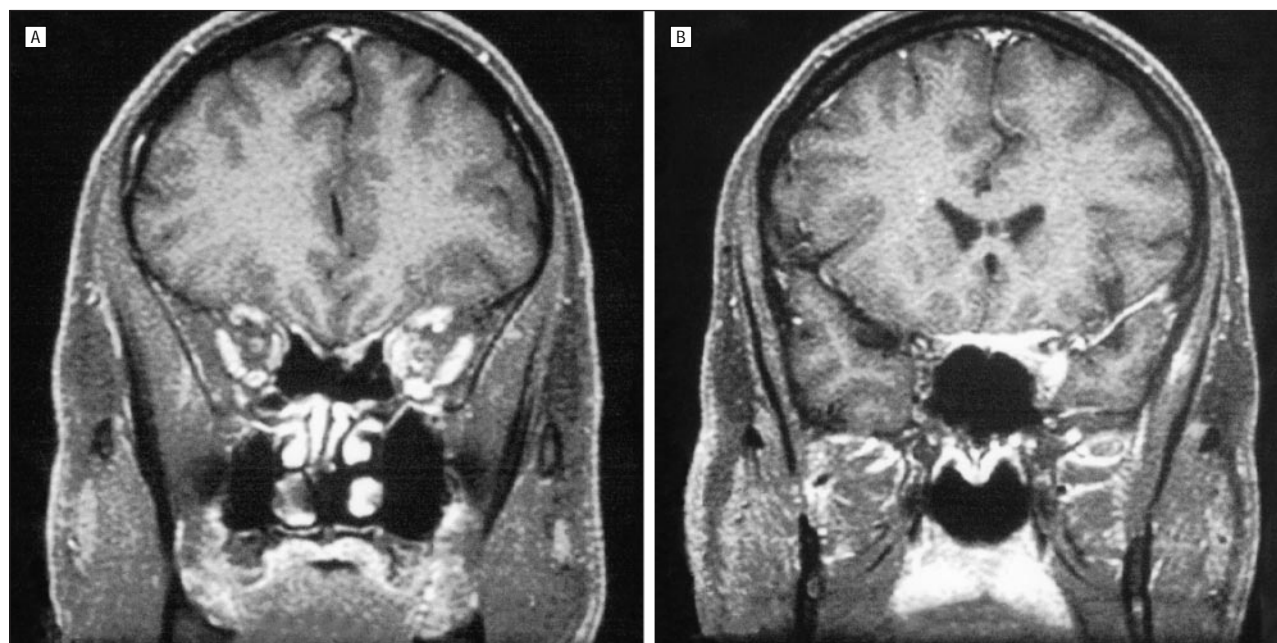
Patient 2. A magnetic resonance imaging scan with contrast infusion obtained 4 months after the onset of visual symptoms. A, The coronal view through the orbital apex shows enhancement around the left optic nerve. There is also mild enlargement and enhancement of extraocular muscles. B, The coronal view more posteriorly demonstrates extension of the inflammatory process intracranially to the anterior cavernous sinus and along the planum sphenoidale.
